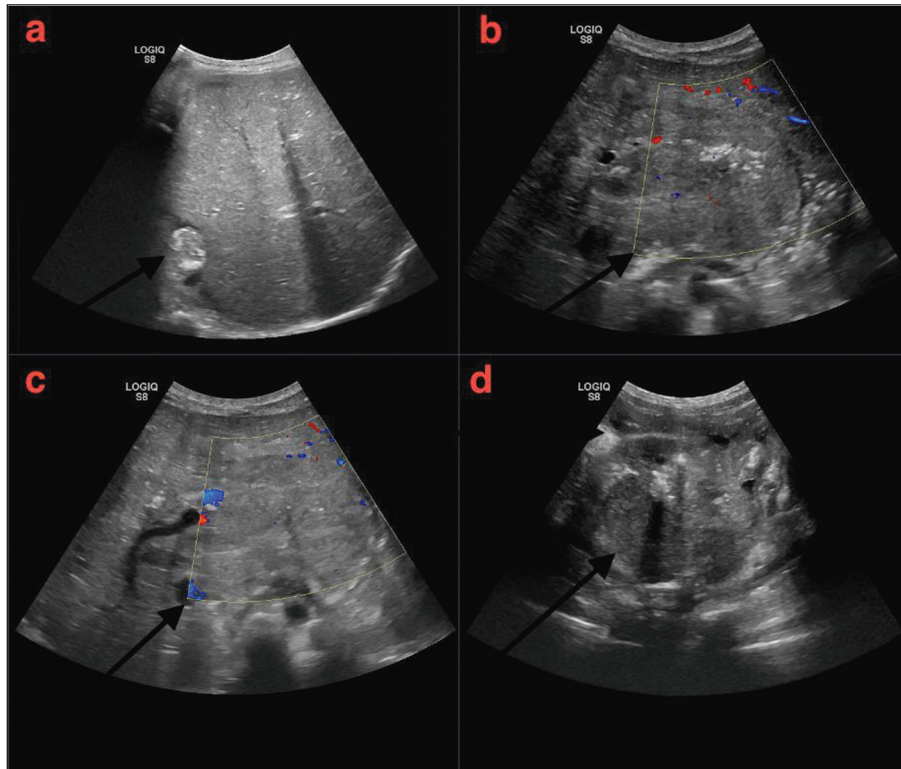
Abdominal ultrasonography.
